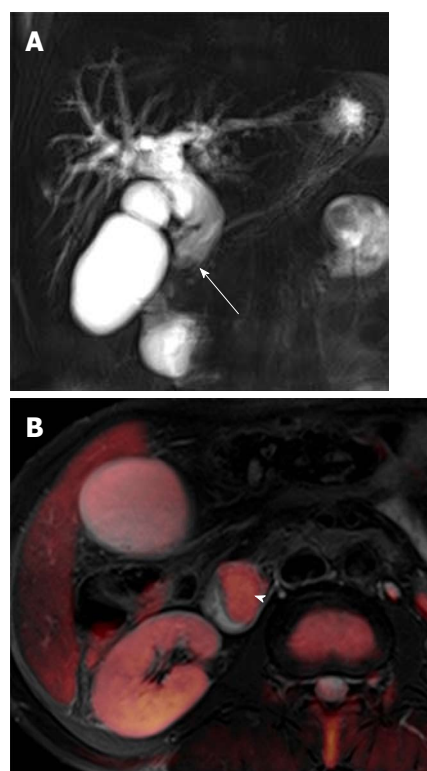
Ampullary carcinoma in a 63-year-old man. A: Coronal image from thick-slab single-shot MRCP shows marked bile duct dilatation with abrupt narrowing (arrow) at the distal common bile duct; B: Fusion image of T2-weighted and diffusion-weighted imaging at $b = 800 \text{ s/mm}^2$ shows an ampullary mass with hyperintensity (arrowhead). MRCP: Magnetic resonance cholangiopancreatography.
